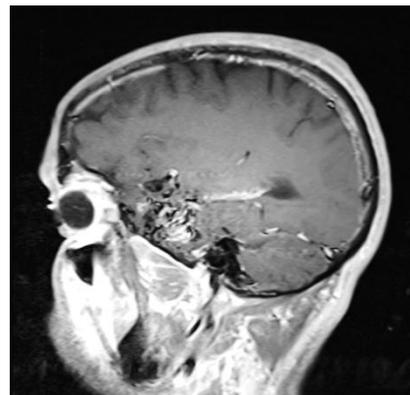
Sagittal MRI T1 weighted image shows AVM in the left cerebral hemisphere
